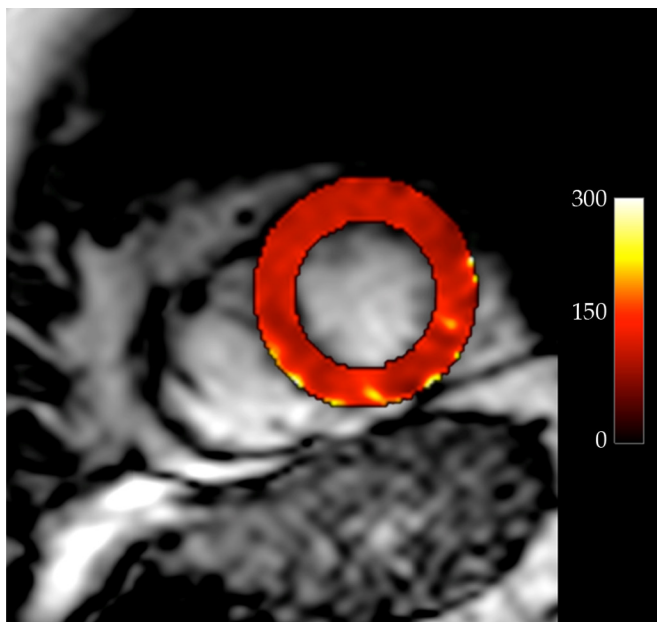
Cardiac magnetic resonance image in the left ventricular short-axis view with overlying color-coded T2 map showing increased T2 values, indicating diffuse myocardial edema as a sign of myocarditis. The color bar shows T2 values. Adapted from the personal collection of Esben SS Hansen, MSc., Aarhus University Hospital, Denmark.
